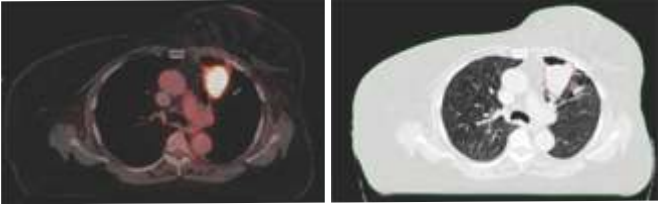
85 year old female, CT and CT-PET shows stage - I, Lung cancer – Adenocarcinoma. CT PET (A) and CT scan of thorax (B) of a patient treated with SBRT
